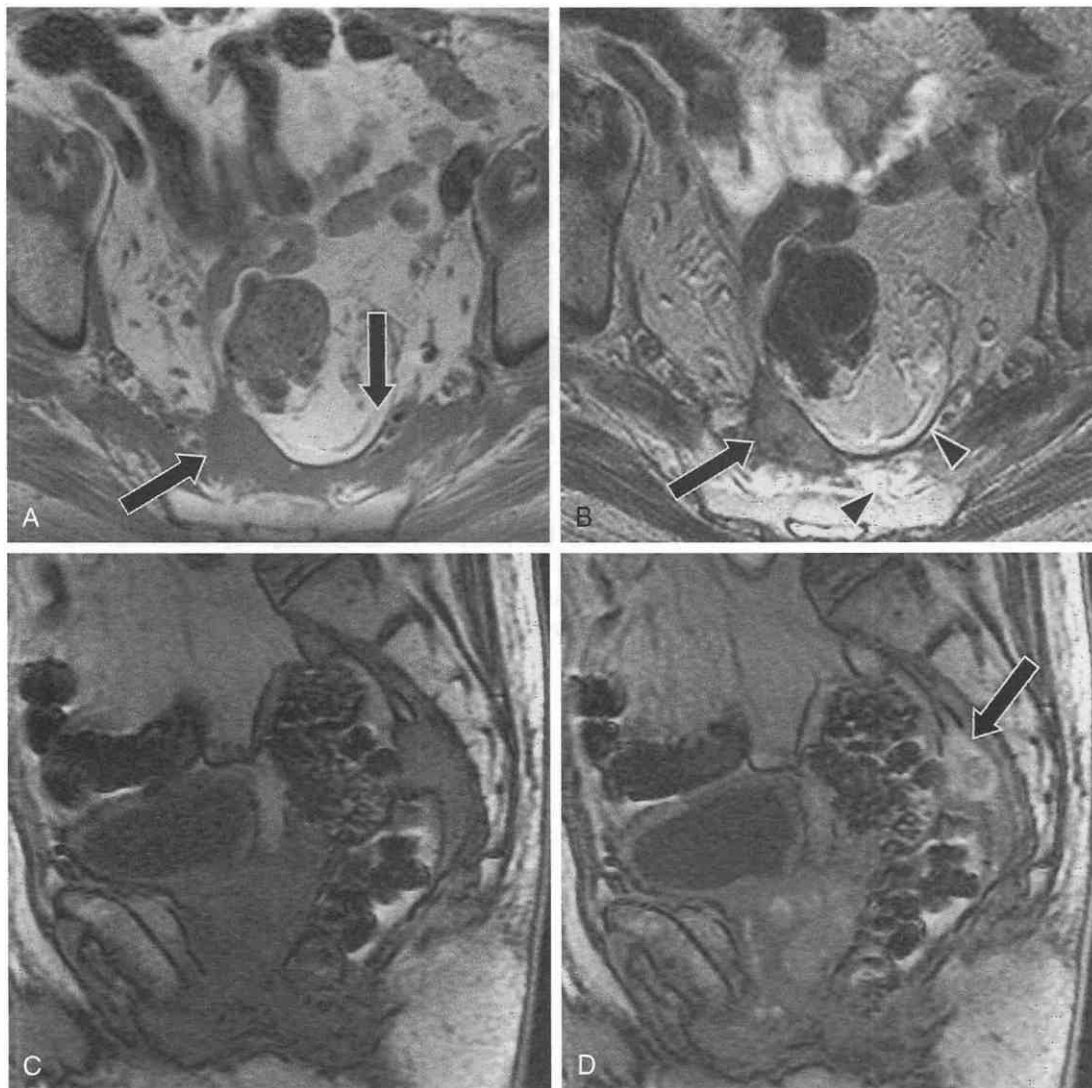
Tumor recurrence in a patient after proctectomy for rectal carcinoma. *A*, Axial T1-weighted image shows a presacral mass (arrows) with slightly more fullness on the right than on the left. *B*, Axial T2-weighted image shows an intermediate signal intensity to the fuller area on the right (arrow), whereas some of the presacral tissue consists of edema and low-signal-intensity scarring (arrowheads). Sagittal T1-weighted, fast spoiled gradient-echo images before (*C*) and after (*D*) administration of gadolinium show rapid enhancement of the nodular area (arrow), indicating recurrent rectal tumor.
